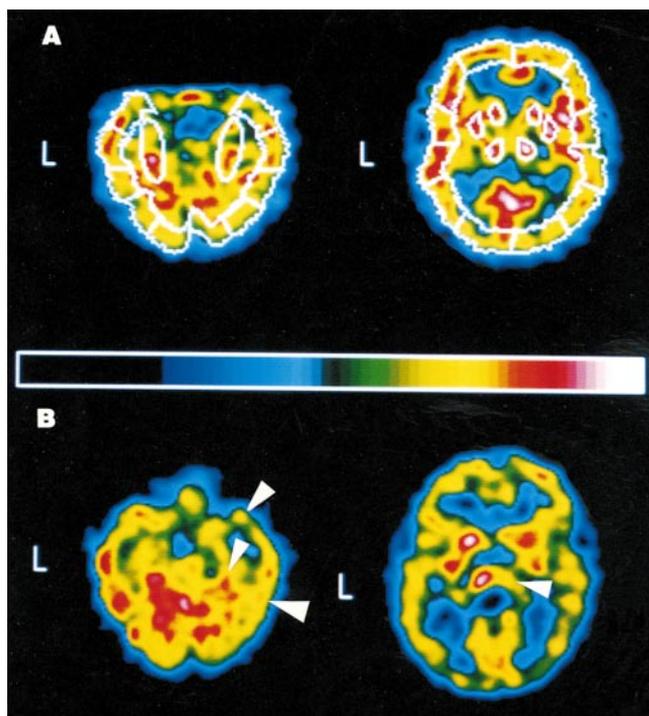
(A) ROIs drawn over 2 transaxial sections parallel to bicommissural line. ROIs were drawn automatically around superficial cortex by software option; symmetric ellipsoid ROIs are drawn by hand around mesiotemporal cortex (left), and symmetric irregular ROIs are drawn by hand around thalami and basal ganglia (right). (B) Examples of brain hypoperfusion in 2 boys with BD. (Left) Cortical hypoperfusion of right mesio- and laterotemporal cortex (arrowheads) in patient 2 (second SPECT examination); patient also had hypoperfusion of head of right caudate nucleus. (Right) Hypoperfusion of right thalamus (arrowhead) (asymmetry of head of caudate nucleus did not reach cutoff asymmetry value of 10%) in patient 1 (first SPECT examination). ^{99m}Tc -HMPAO uptake values are expressed according to common color scale. L identifies left side of brain.
